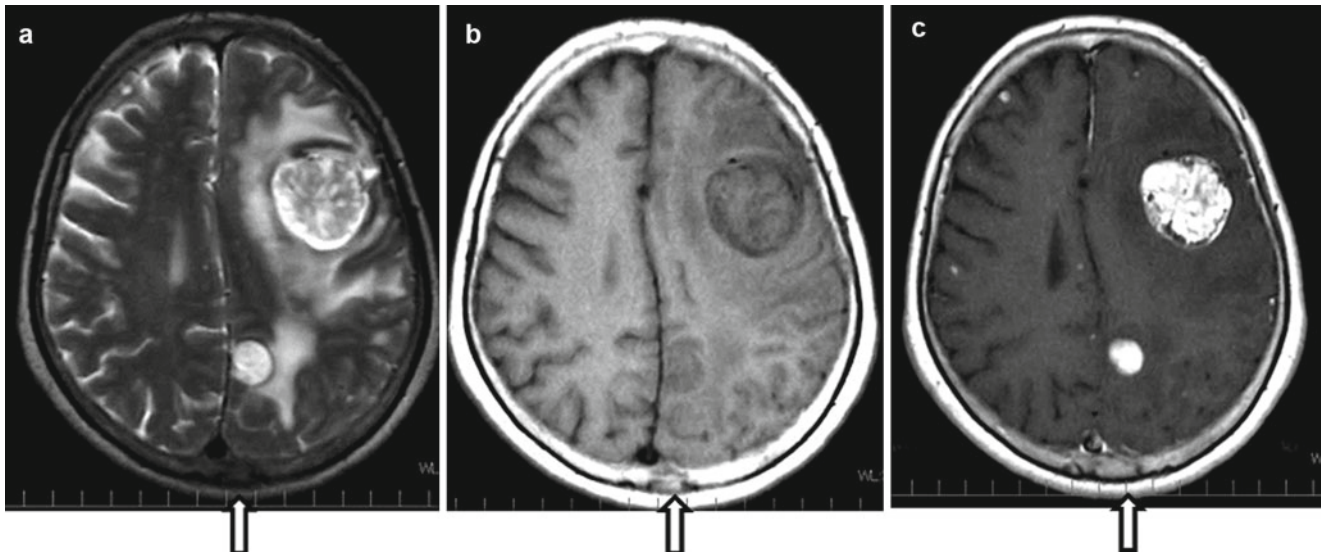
Multiple parenchymal and bone (*arrow*) metastases of thyroid carcinoma. Hypervascular tumors have heterogeneous signal intensity on T2-weighted (a) and T1-weighted (b) images. Note the prominent heterogeneous contrast enhancement (c). The capsule of the parenchymal tumors is clearly seen
